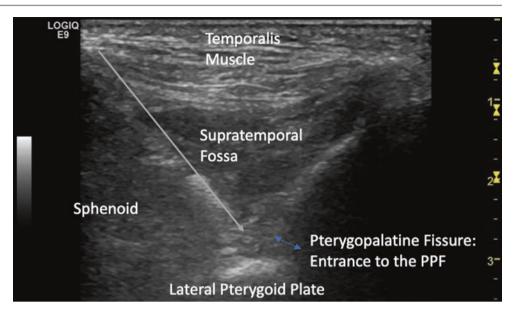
(a) An ultrasound image comparing the three main approaches with anatomic landmarks. Yellow needle (1) is the posterior-to-anterior infrazygomatic approach, while the red needle (2) is the anterior infrazygomatic approach, with (2a) being the contact with the lateral pterygoid plate, followed by movement into the pterygopalatine fossa (2b). The blue needle represents the suprazygomatic approach, with (3a)
